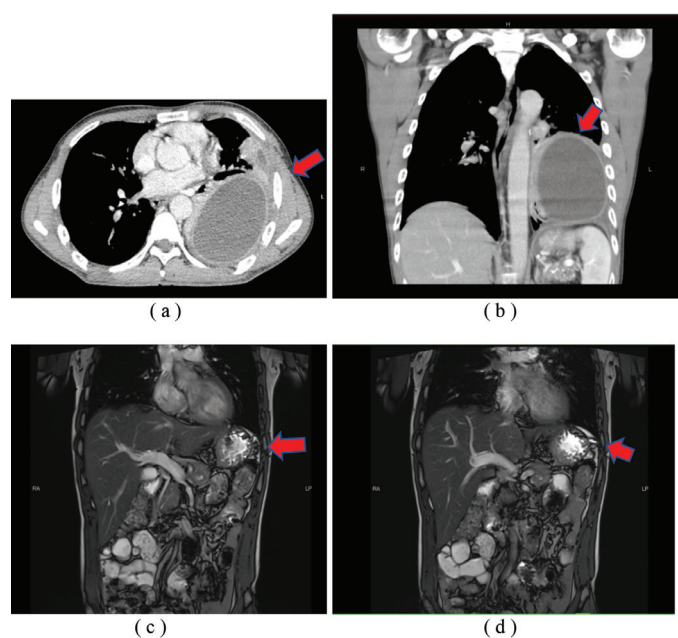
(a, b) are the contrast enhanced CT thorax showing large peripheral rim enhancement of fluid density in the left lower lobe pleural cavity, which extends anteriorly into the inferior lingula region with split pleural sign, which is suggestive of left lung empyema. (c, d) are MRCP suggestive of chronic pancreatitis, pancreatic tail thickening with filling defect seen within the pancreatic duct at the distal part of the body.
